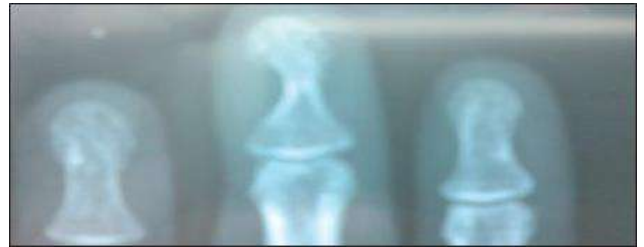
X-ray showing scalloping on the radial side of distal phalanx of middle finger.
